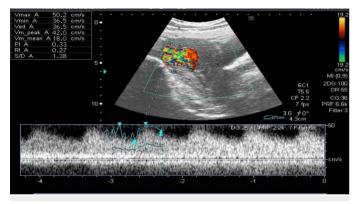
Doppler of spiral arteries obtained from the same patient as shown in figure 4
